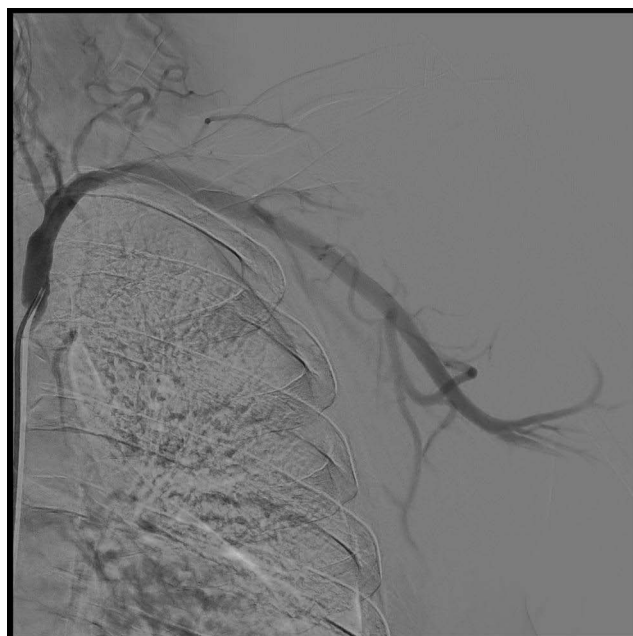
Fluoroscopic X-ray image during the percutaneous angioplasty indicating re-canalization of the previously stenosed segment.
